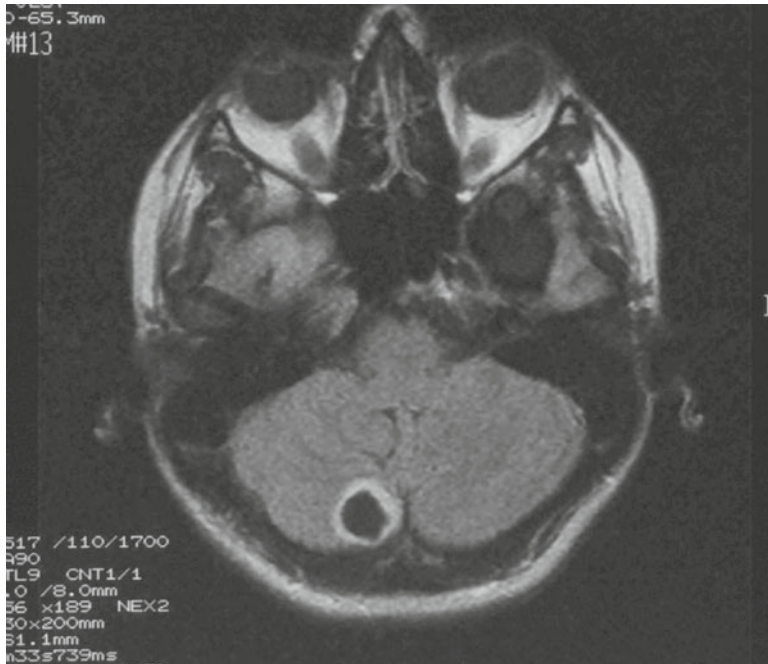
Contrast enhanced axial FLAIR-weighted MRI scan of the head showing cystic tumor of the right cerebellar hemisphere
